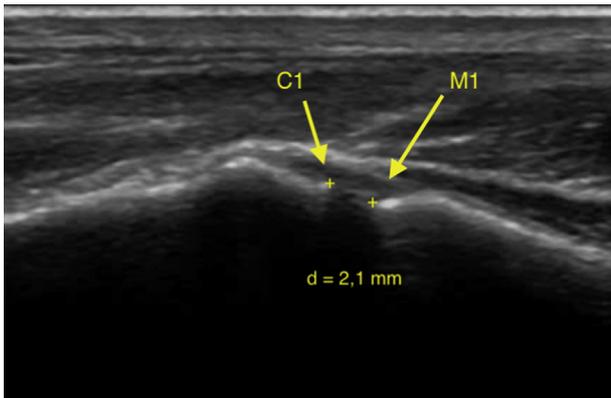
Ultrasound measurements during the stress manoeuvre. C1: edge of the joint surface of the medial cuneiform; M1: edge of the joint surface of the first metatarsal; d: distance between C1 and M1 in the stress position (stress plantar TMT1 gap).
